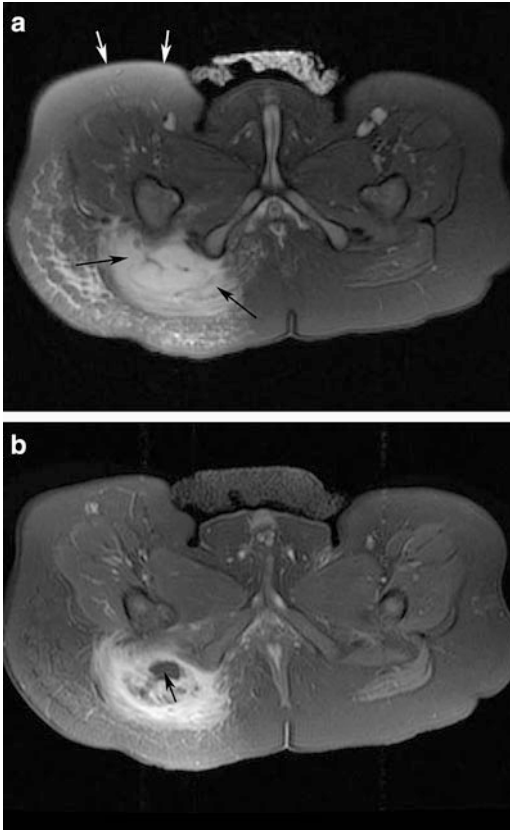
MRI of the pelvis in an 8-month-old child with pyomyositis performed on a 1.5 T magnet with a cardiac coil. (a) Axial T2-FSE fs image through the lower pelvis demonstrates areas of poor fat suppression along the right thigh (*white arrows*). An area of confluent signal abnormality is clearly appreciated (*black arrows*) in the posterior soft tissues adjacent to the right ischium (*black arrows*). (b) Axial T1 fs image performed after intravenous contrast administration demonstrates abnormal enhancement in the same area, with a focal non-enhancing abscess (*arrow*)
